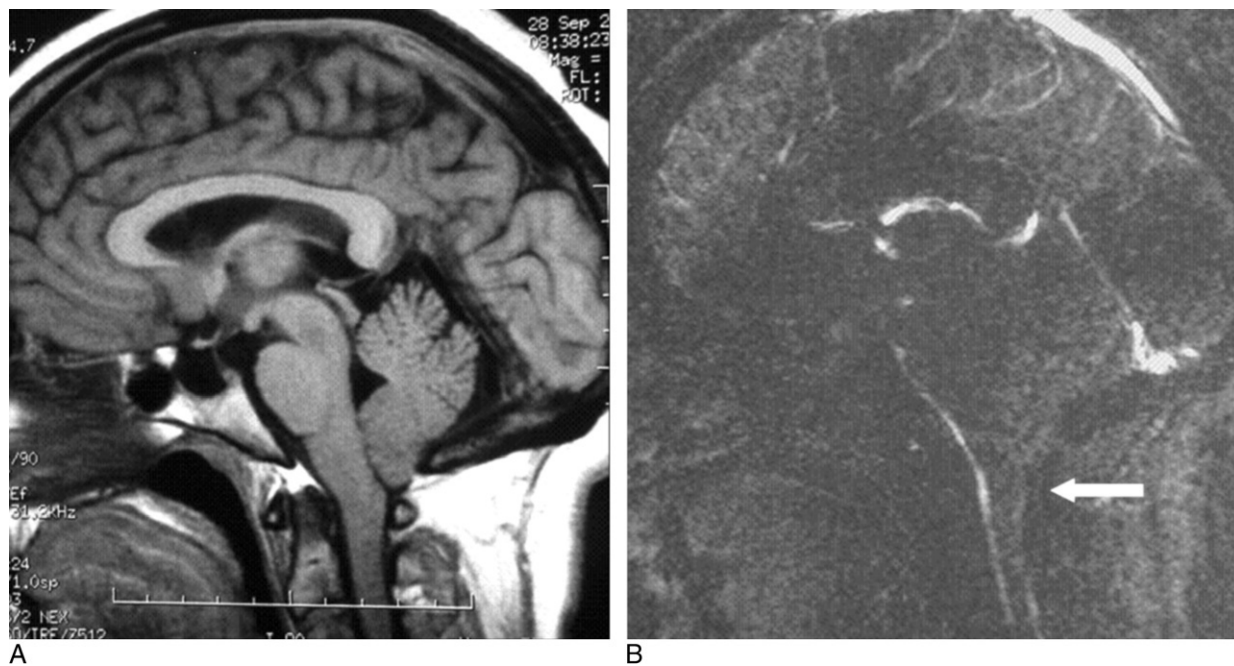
(A) Magnetic resonance imaging (MRI) of a 33-year-old female with Chiari type I presenting as cough headache. (B) Sagittal cine phase-contrast MRI showing difficulties in cerebrospinal fluid circulation posteriorly in the foramen magnum region (arrow).
